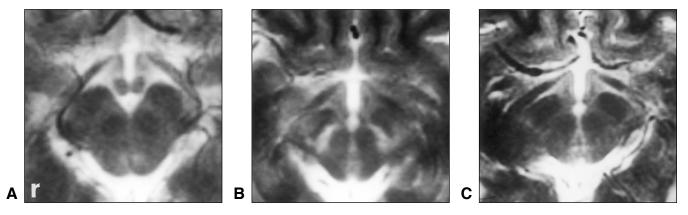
A magnified brain MRI on T2W shows an increased signal intensity, particularly in the substantia nigra, in the patient with WD (B), as compared with those of a normal control (A) and a PD patient (C).
